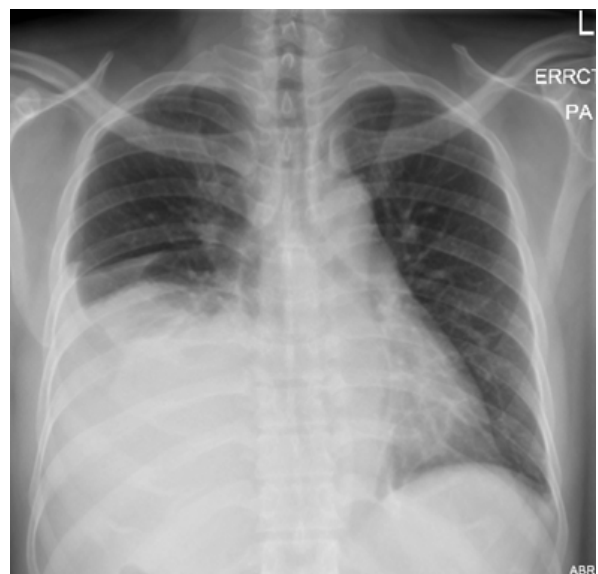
Chest x-ray showing fluid on right side
